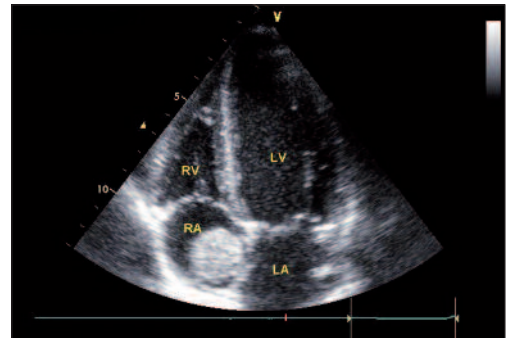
From apical four chamber window the mass can be seen like a smooth-edged ball.
